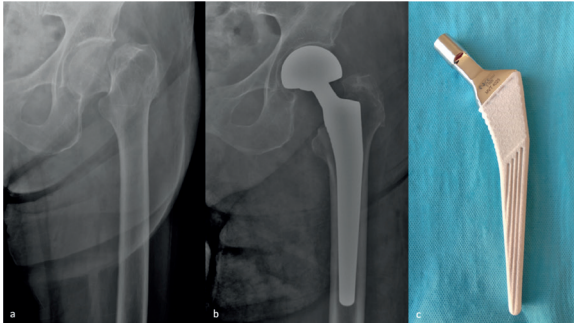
Radiographs of an 81-year-old woman with a proximal femur fracture
